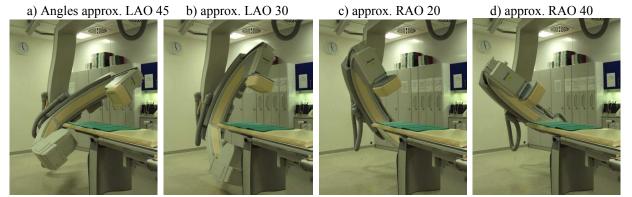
For rotational angiography the C-arc X-ray gantry rotates with 30° degrees/second over the patient table (Fig. 1a to 1d)). High speed personal computers linked to the X-ray modality reconstruct 3D cardiac anatomy images from the rotational angiography X-ray acquisition.
